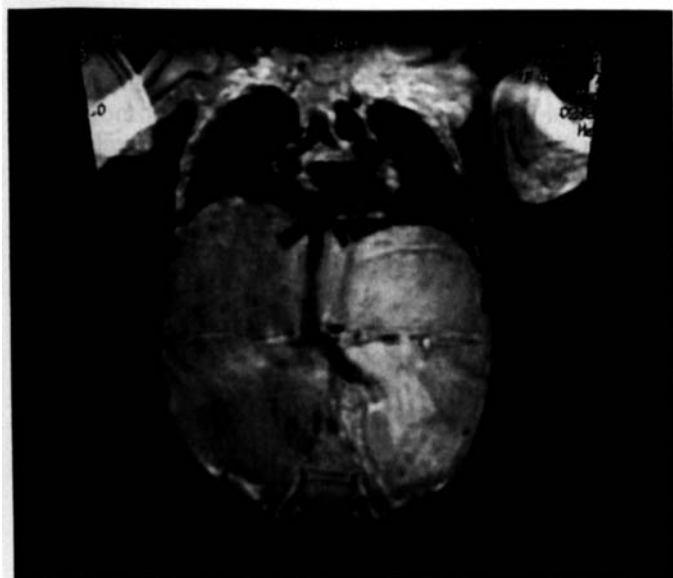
Pretransplant MRI of case 2. Recipient's IVC was obliterated just distal to the renal veins
